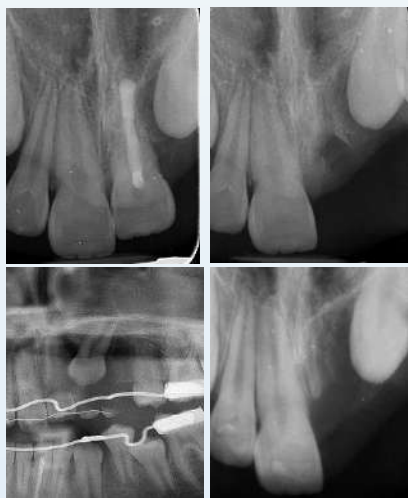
Preoperative radiograph (a), Postoperative (b), 4 months panoramic (c), 12 months follow-up (d)
